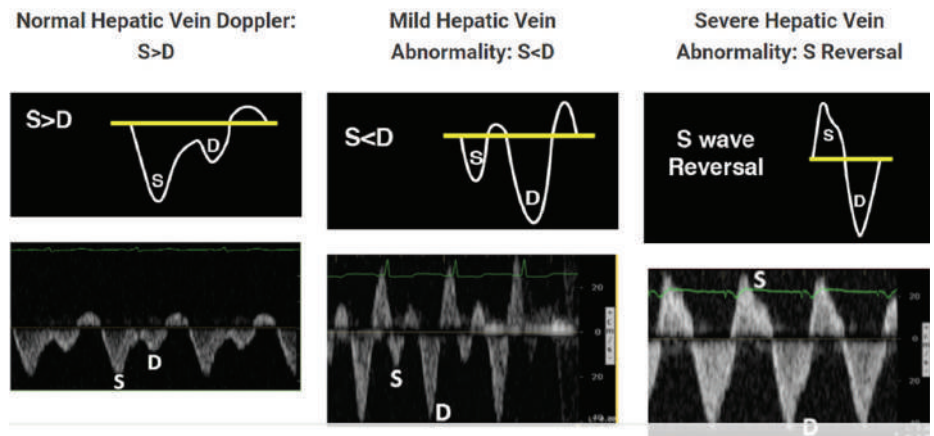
Hepatic vein doppler flow.
